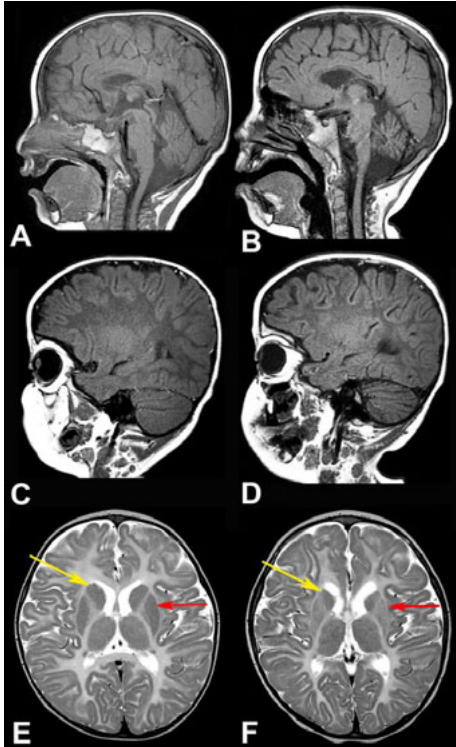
Atypical MRI abnormalities.
